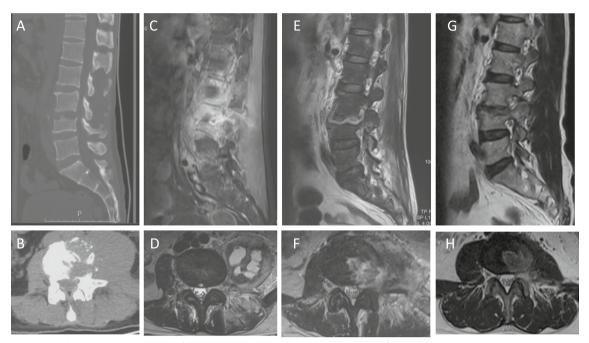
A 52-year-old male patient presented left lower extremity pain and weakness persisting for over two months. A, B: Lumbar spine sagittal and horizontal CT images revealed signal alterations in the L3/4 intervertebral space, accompanied by significant destruction of the superior endplate of L4; C, D: Enhanced magnetic resonance imaging exhibited a substantial fluid signal in the left psoas major region; E: Postoperative MRI, conducted three days after the operation, demonstrated successful excision of the abscess in both sagittal and axial imaging; F, H: Subsequent MRI evaluations, conducted three months post-surgery, revealed complete resolution of the abscess and no sign of recurrence
